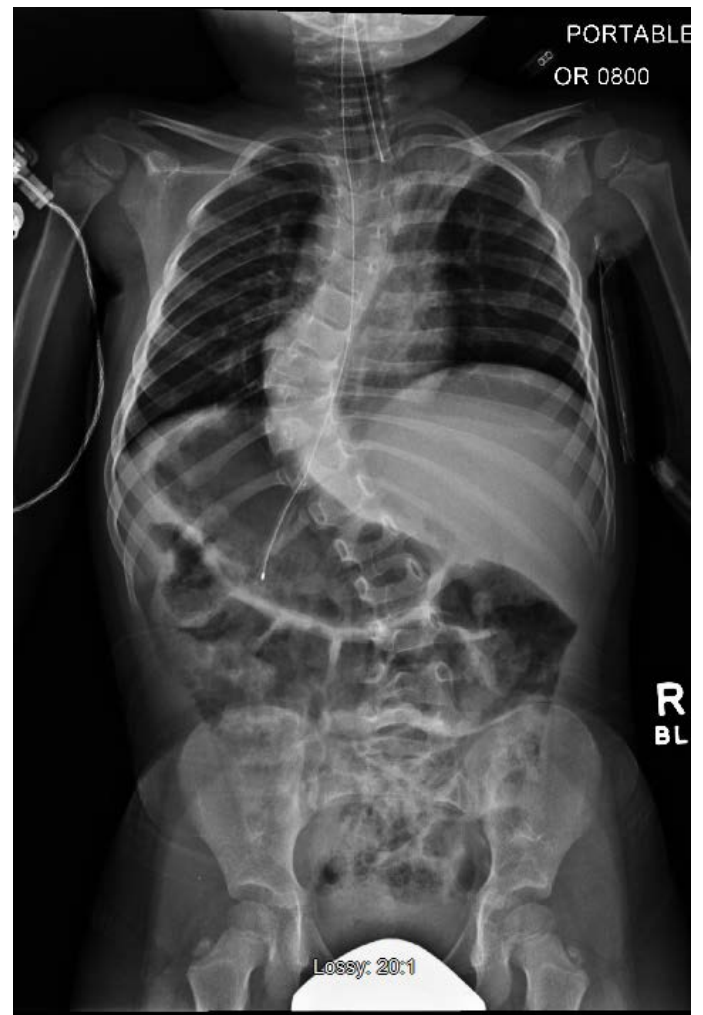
A typical pre-casting radiograph is obtained with a grid.
